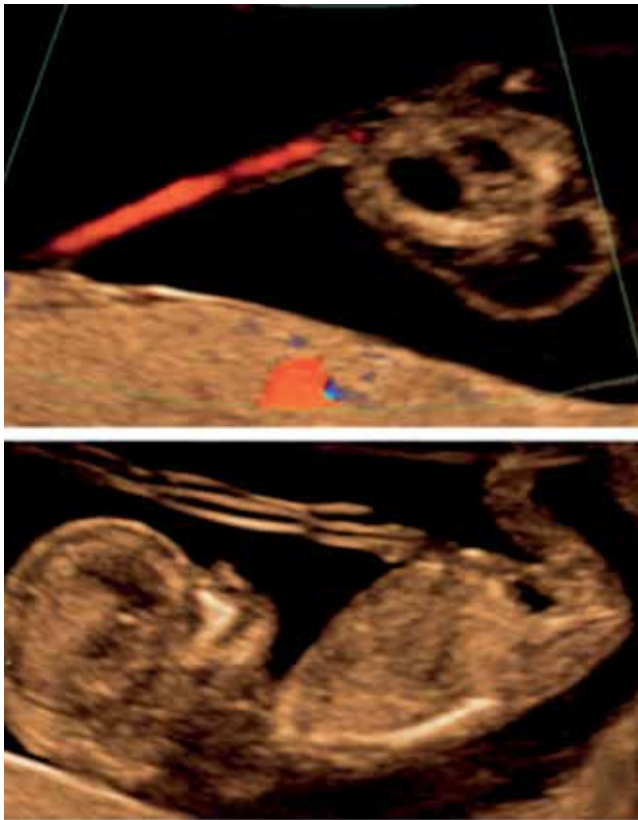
Upper image: Acardiac twin with retrograde flow in the umbilical cord. Lower image: Normal recipient twin. Adapted from ultrasound Obstet Gynecol. Pagani et al. [124].
